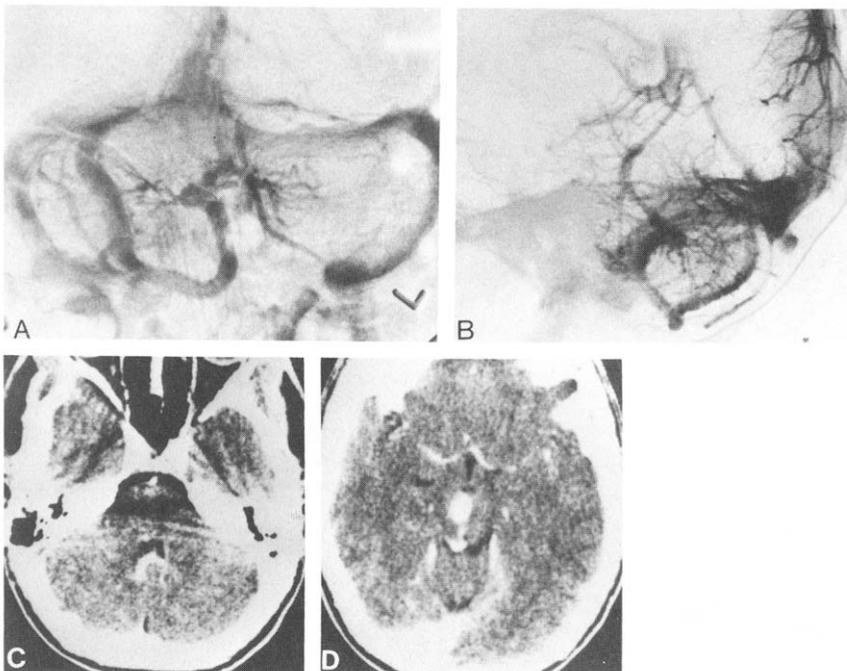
Case 2. (A) Anteroposterior and (B) lateral views of the left vertebral angiograms in the venous phase demonstrate enlarged veins with numerous dilated medullary veins adjacent to the fourth ventricle. (C) A CT scan with contrast shows prominence of vein of lateral recess of fourth ventricle and (D) an area of high attenuation with microcalcifications in the right midbrain.
